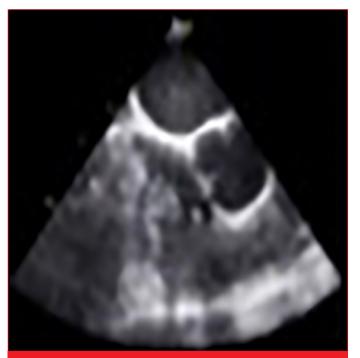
Mobile mass. Mobile mass around the lead on transesophageal echocardiography
